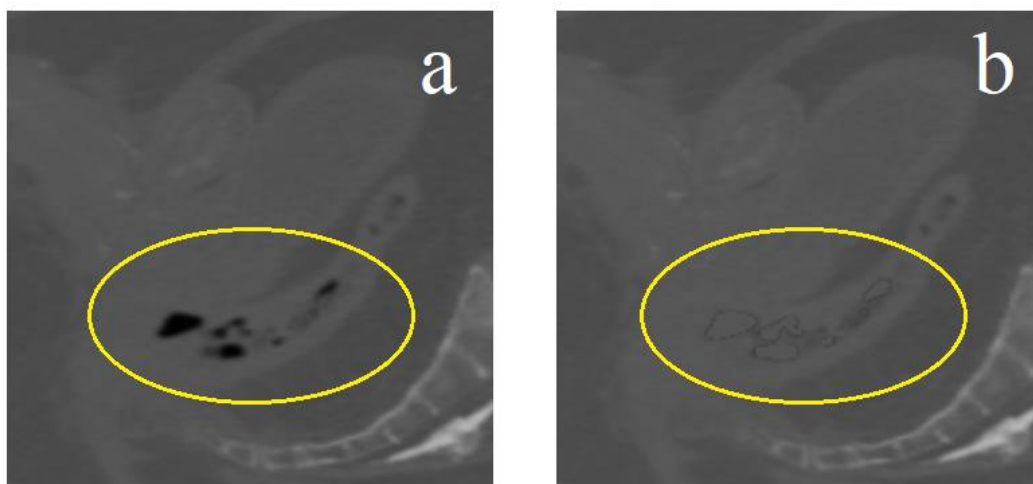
Gas pockets correction. (a) Air pockets in the original planning CT and (b) corresponding corrected region in the virtual CT.
